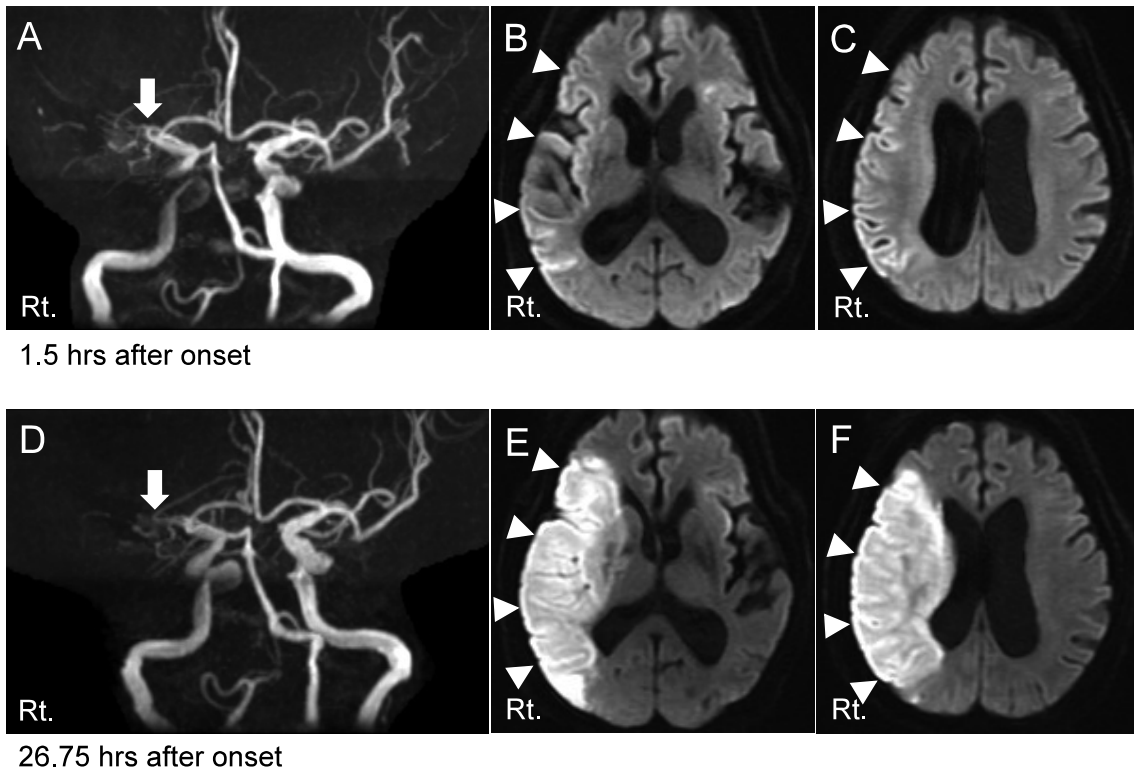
A : MRA showing occlusion of the right MCA at the stem 1.5 hours after onset (arrow). B, C : DWI showing slight hyperintensity in the right MCA territory (arrowhead). D : MRA shows occlusion of the right MCA at the stem 26.75 hours after onset (arrow). DWI showing bright hyperintensity in the right MCA territory without recanalization of the MCA (arrowhead). MRA, magnetic resonance angiography ; MCA, middle cerebral artery ; DWI, diffusion-weighted imaging.
